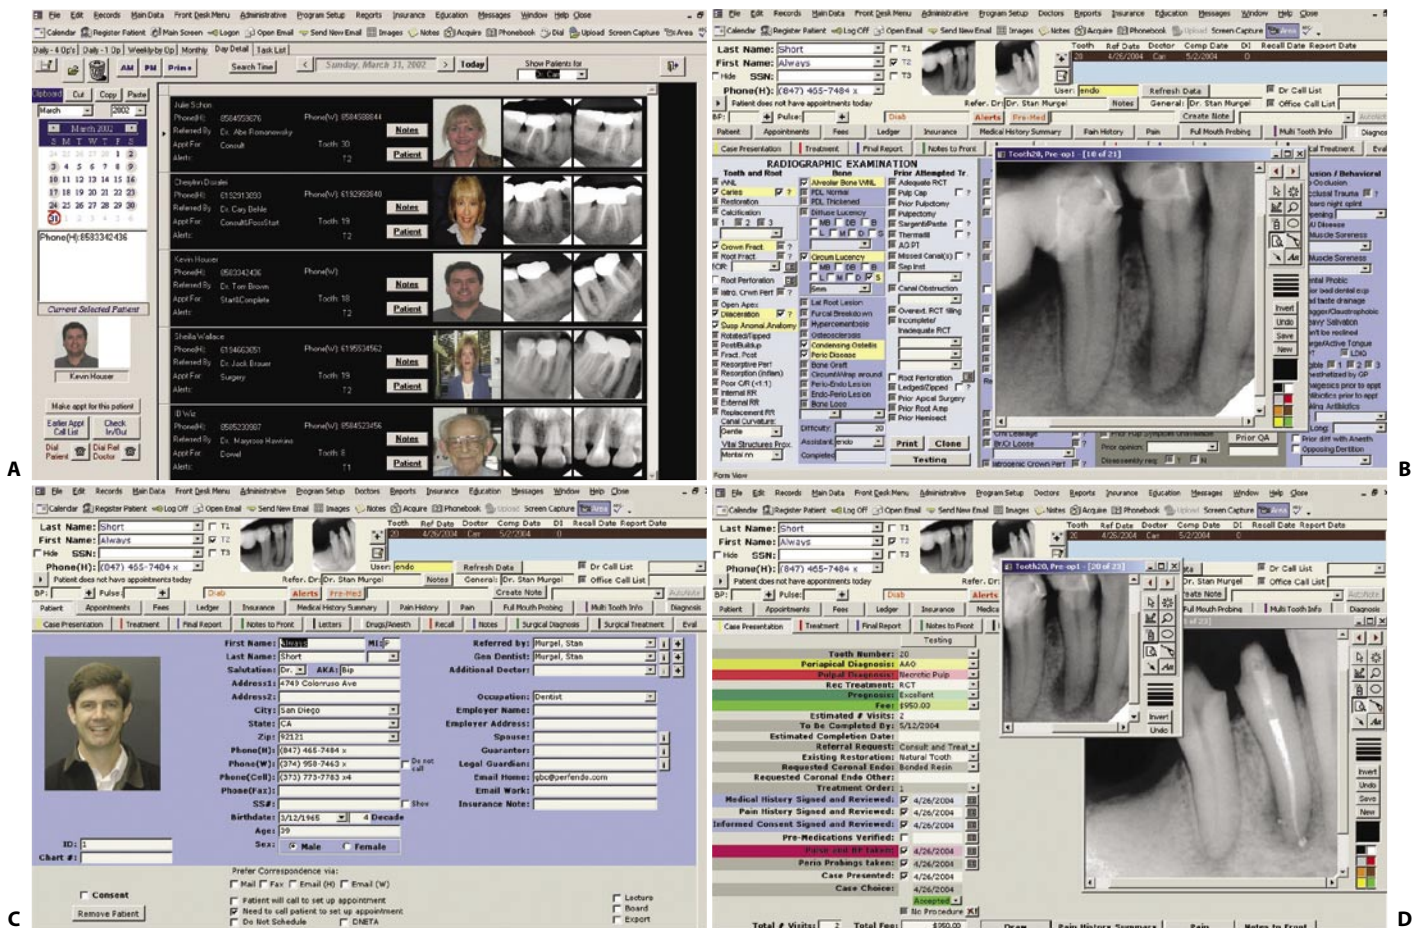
A-D. Radiographic and clinical images may be filed in each patient's clinical card. An example of the software “The Digital Office” (TDO). Courtesy of Dr. Gary Carr.
